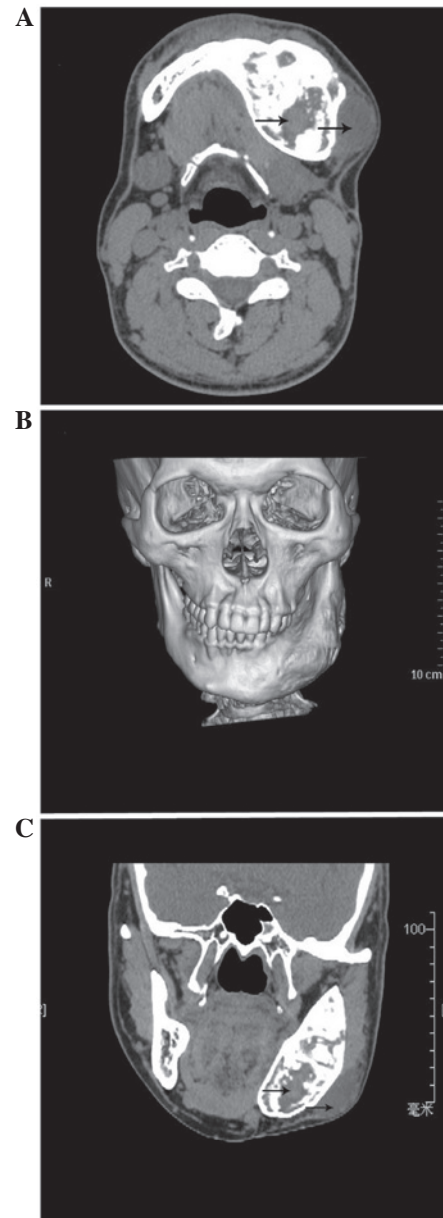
(A) Coronal computed tomography (CT) in the oral and maxillofacial regions showing a solid soft-tissue mass within the left musculus buccinator (right arrow) and radiolucent cystic lesions with frosted glass margins in the left body of the mandible (left arrow) (B) Three dimensional CT reconstruction in the oral and maxillofacial regions showing bone widening and local destruction of the adjacent cortex. (C) Axial CT in the oral and maxillofacial regions showing a solid soft tissue mass within the left musculus buccinator (right arrow) and radiolucent cystic lesions with frosted glass margins in the left body of the mandible (left arrow).
